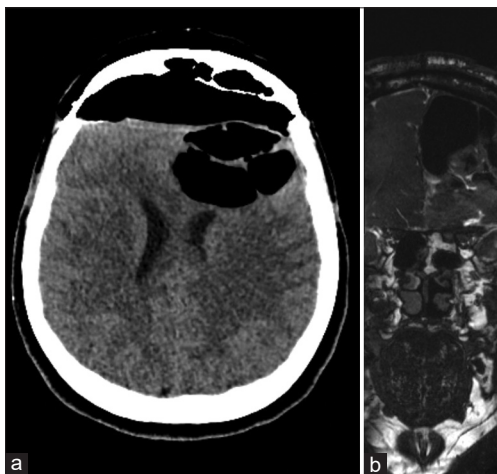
Axial head computed tomography scan (a) and coronal T2-CISS 3D magnetic resonance imaging (b) showing the presence of pneumocephalus with a small defect in the posterior ethmoidal plane close to the sphenoidal suture with pneumocephalus.
